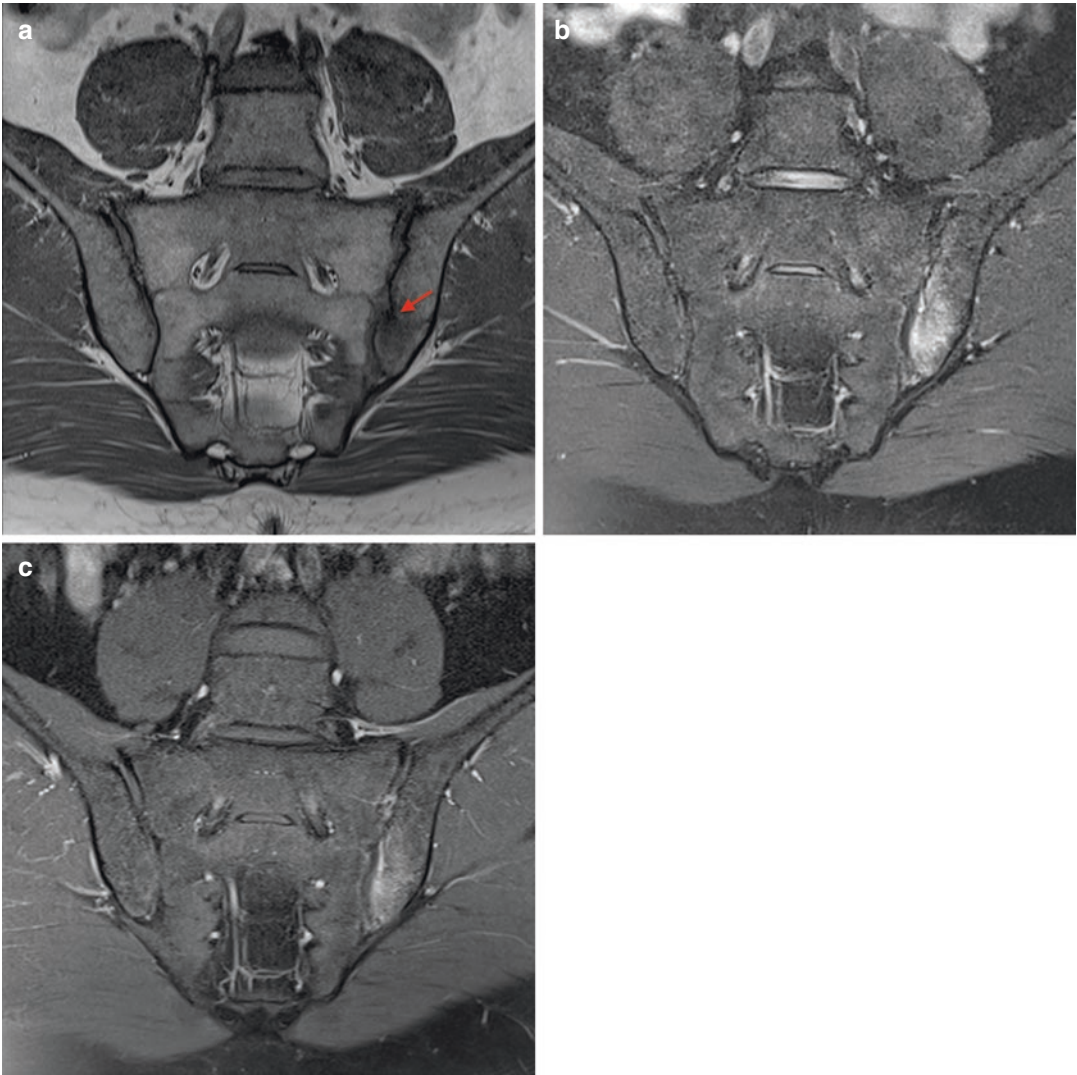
(a–c) 33-year-old male with psoriatic arthritis. (a) Coronal T1 (b) coronal fat-suppressed proton-density and (c) coronal fat-suppressed post-contrast, T1w MR images depict extensive BME adjacent to the left SIJ, on
